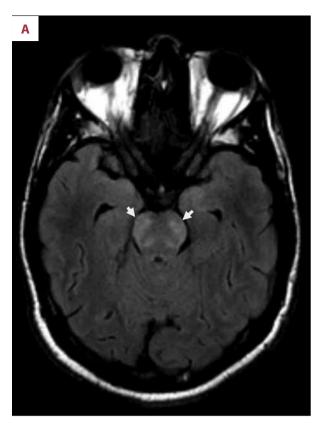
(A, B) Axial and coronal postgadolinium T1-weighted images, respectively, showing diffuse nodular as well as smooth basal meningeal enhancement around the midbrain and pons (arrows).
